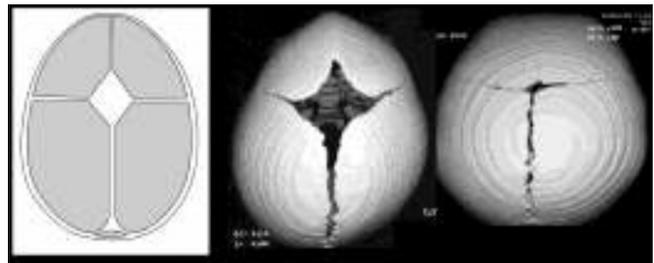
Anatomical picture of the anterior fontanelle; size variation in normal neonates as shown by CT volume-rendered reconstruction
